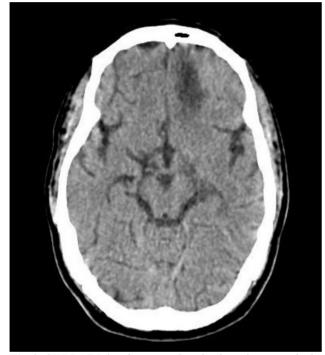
CT BRAIN showing non-enhancing hypodense area in the left parafalcine frontal lobe with loss of grey matter differentiation suggesting ACA infarct and oedema.
